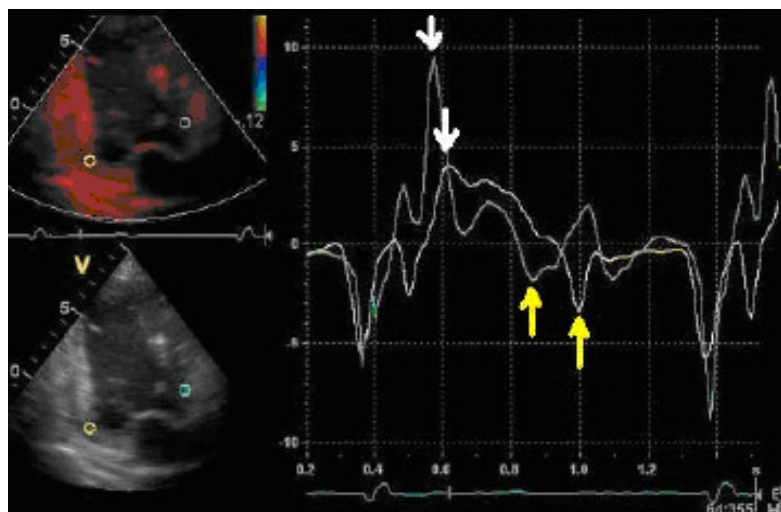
The apical two chamber view shows only mild (30 ms) systolic and significant (130 ms) diastolic delay of basal inferior segment over the basal anterior segment. The peak systolic (white arrows) and diastolic (yellow arrows) velocities are shown by the arrows.
